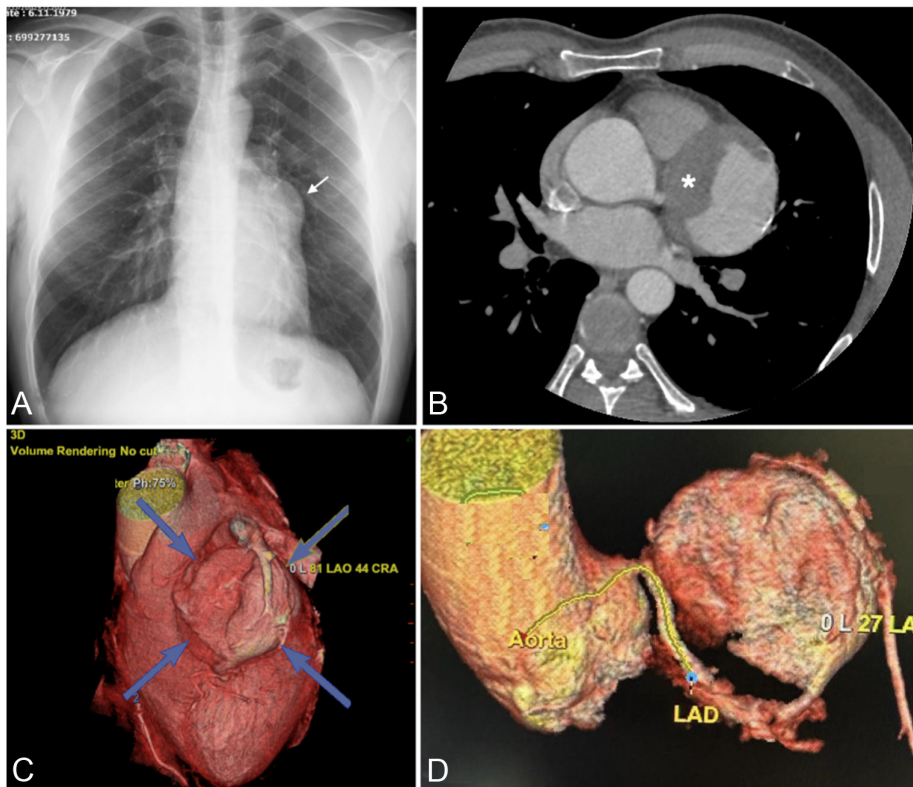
(A) Chest radiograph shows an abnormal radiographic finding along the left border of the heart (arrow). (B) Axial section computed tomography shows the huge aneurysm of the left anterior descending artery with intramural thrombus (asterisk). (C, D) Reconstructed 3D coronary computed tomography shows a large aneurysm involving the proximal left anterior descending artery.
